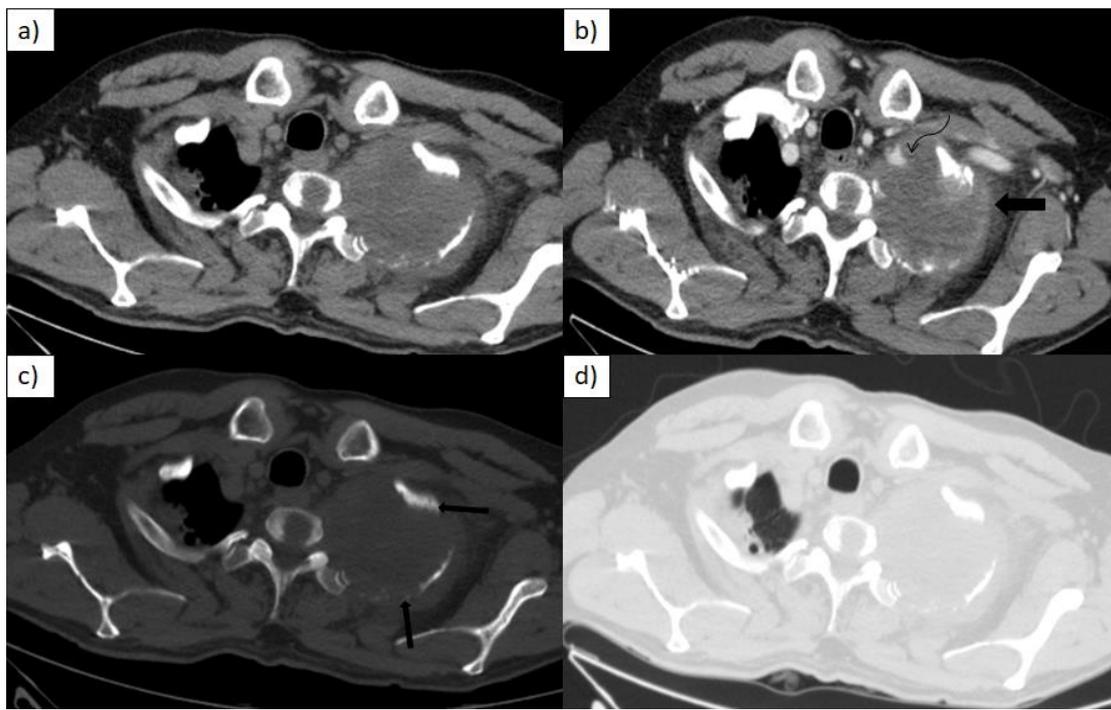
[a]Plain Mediastinal window, b) Post contrast mediastinal window, c) bone window & d) lung window]: Axial CT thorax shows heterogeneously enhancing necrotic mass in the apical segment of left upper lobe with adjacent bone destruction(straight arrows), encasement of subclavian artery(curved arrow) and extra-thoracic extension(block arrow).
